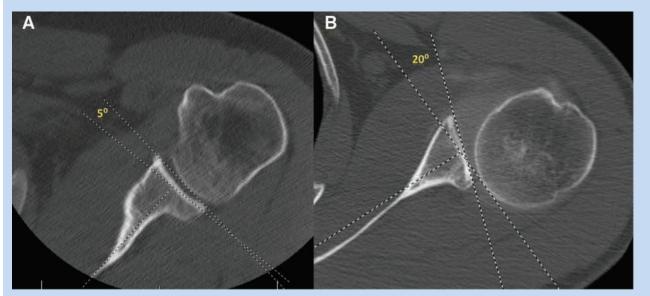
A, computed tomography scan of the shoulder showing normal glenoid version; B, retroversion of the glenoid.
